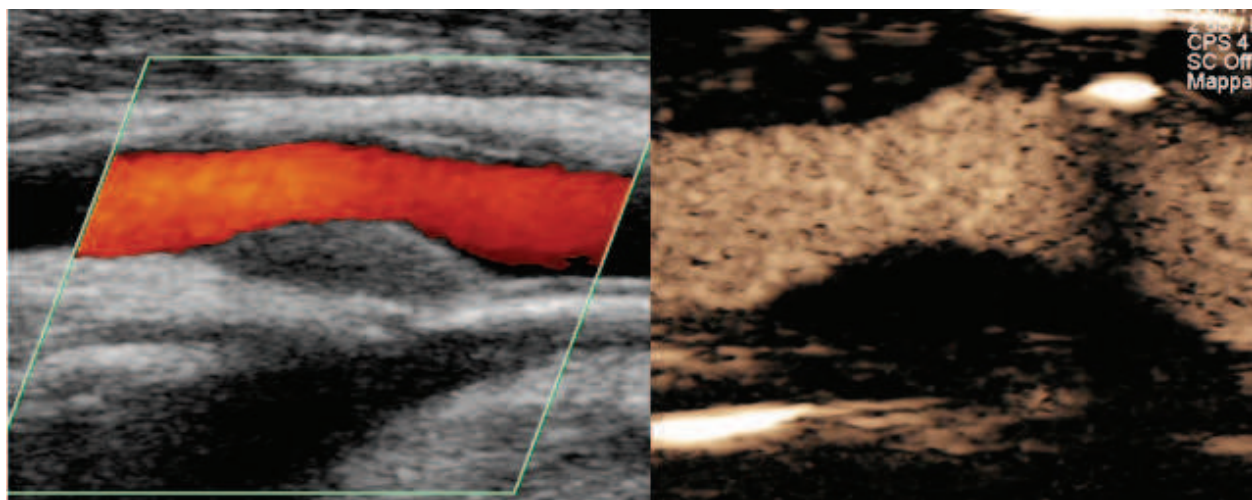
Isoechoic, fibrous plaque with regular surface determining moderate internal carotid artery stenosis in an asymptomatic patient. No vascularization observed at contrast ultrasound.
